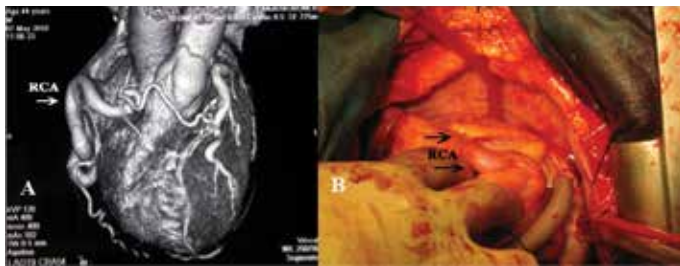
A) Multislice computed tomography angiography view of aneurysmatic right coronary artery originating from the aorta, B) Intraoperative view of the aneurysmatic dilatation of the right coronary artery due to high flow
